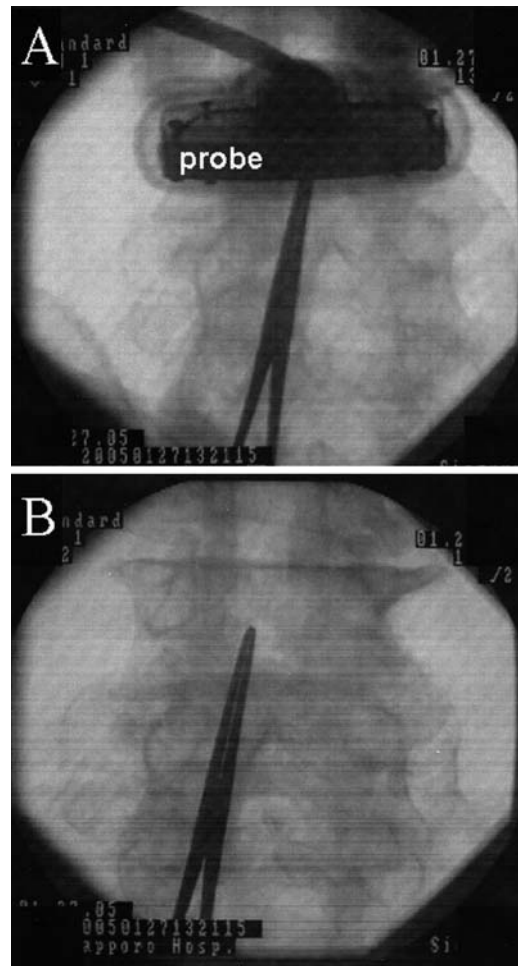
X-ray imaging of the metal hemostat and the ultrasound probe to confirm whether or not identification of the L3/4 intervertebral space by ultrasound imaging was correct. A The tip of the metal hemostat, which would indicate the L3/4 intervertebral space shown in Fig. 1B, was under the ultrasound probe. B The ultrasound probe was removed, and the X-ray imaging proved that the tip of the hemostat was accurately showing the L3/4 intervertebral space
